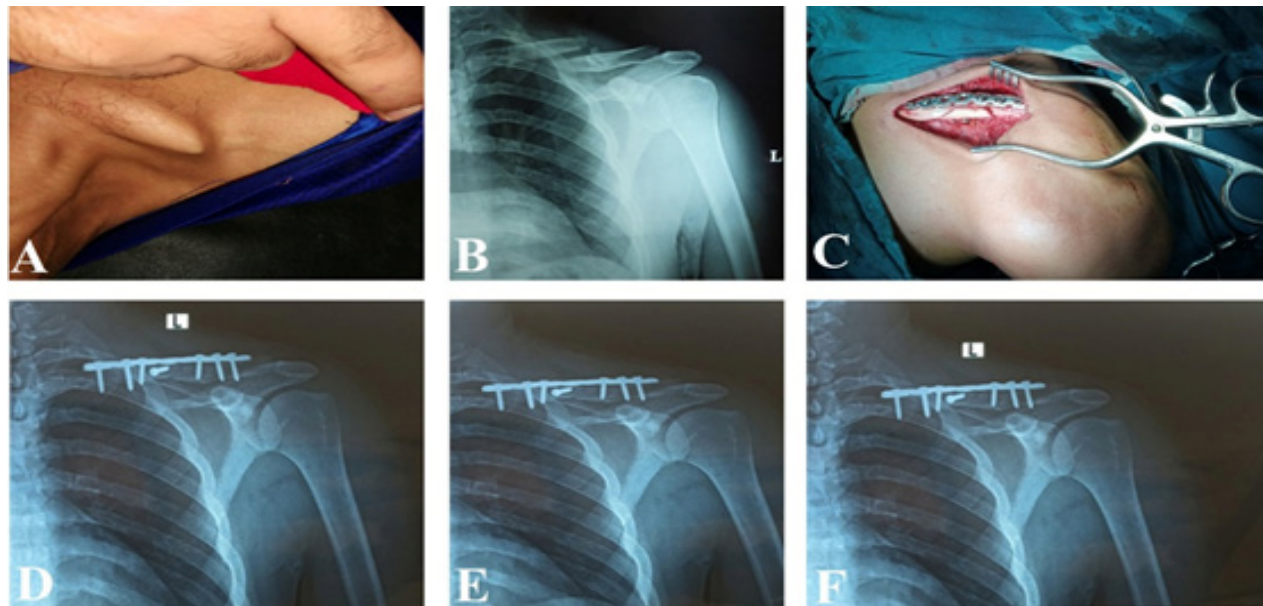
A 32-year-old male manual worker with a displaced midshaft clavicle fracture, with skin tenting. Open reduction and internal fixation was done using lag screw and 3.5 reconstruction plate placed on the superior surface. Full union was achieved without complications; (A): Preoperative clinical photograph; (B): Preoperative radiography; (C): Intraoperative photograph after fixation; (D): Postoperative radiography; (E): 6 weeks follow-up radiography; (F): 6 months follow-up radiography.
